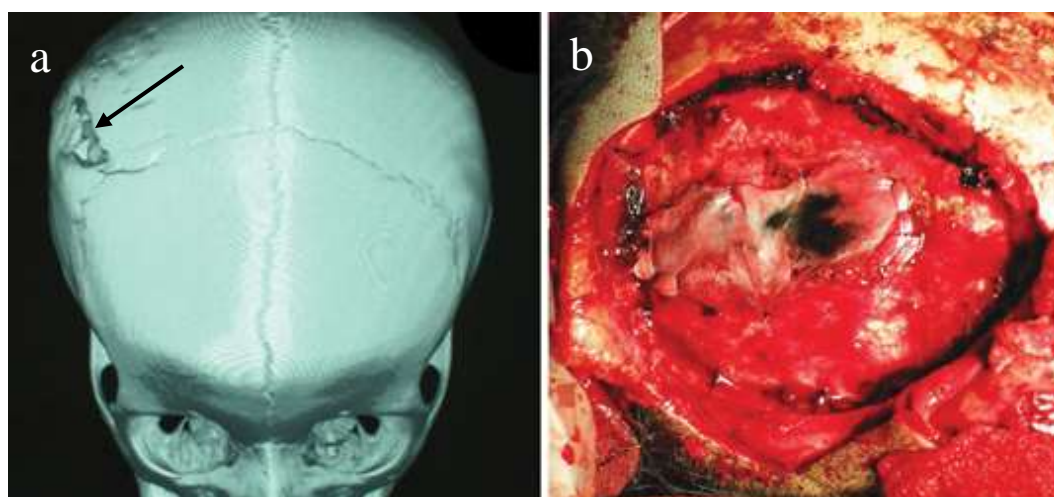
Growing skull fracture in a 2-year-old diagnosed and treated 8 months after the initial traumatic event (a). CT scan image of the right parietal bone erosion from progressive intracranial pulsations on an undiagnosed linear fracture with an underlying dural tear (b) (Lim and Hopper, 2021).
